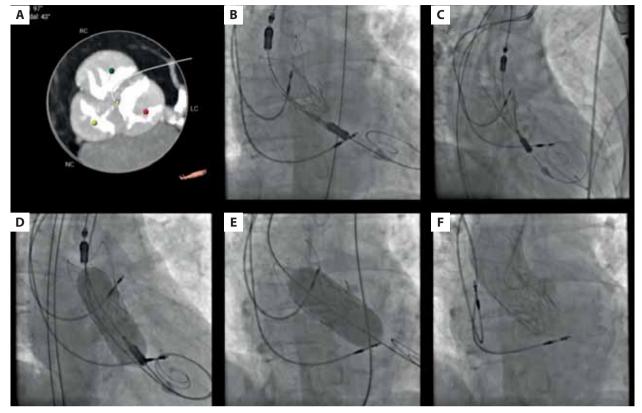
A. Massive aortic valve calcifications showed on computed tomography. B. Severe valve mal opening, three-cusp coplanar view. C. Extreme valve mal opening, cusp overlap coplanar view. D. Initial postdilatation with a semi-compliant 20 mm/40 mm 8 F sheath compatible balloon via an additional guidewire inserted into the left ventricle across the valve prosthesis. E. Postdilatation with a non-compliant 22 mm/40 mm balloon. F. Final angiographic result of ACURATE neo2 implantation
